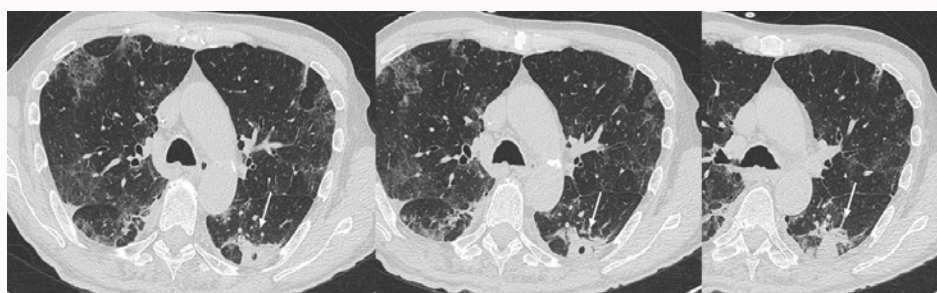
Axial thin-sections unenhanced CT scan show bilateral consolidation areas and cavitations in left lower lobe (arrows).
